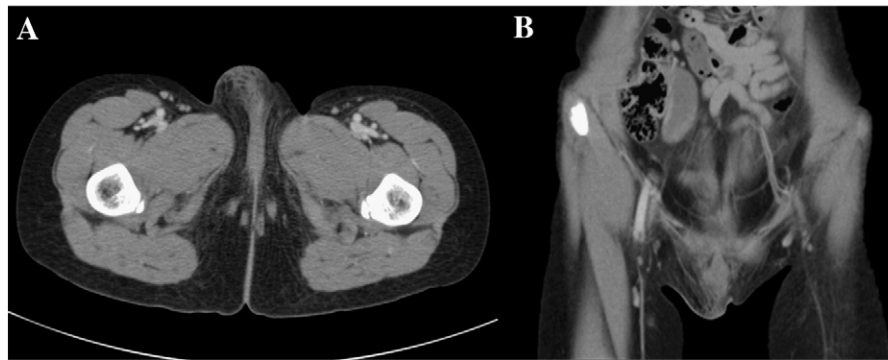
Computed tomography (case 2) showing swelling of the right labium major with infiltrative changes in the subcutaneous layer of the mons pubis and lower anterior abdominal wall. Axial (A) and coronal (B) views.
